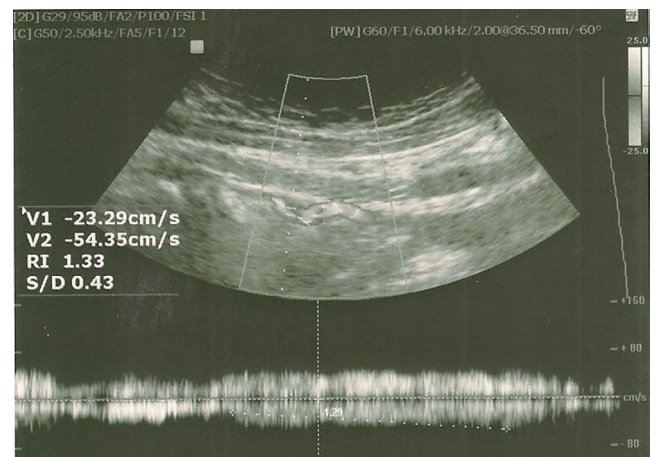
Doppler ultrasound of the right iliac vein. Normal flow pattern in the right common iliac vein
